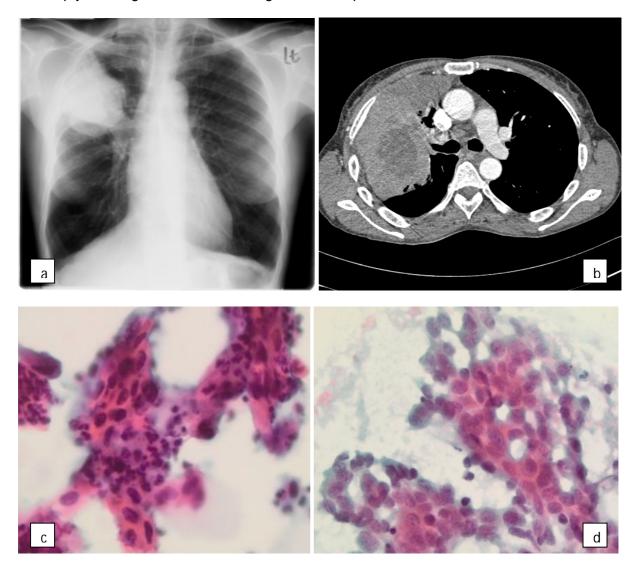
Mass in right upper lobe with associative collapse and lymphadenopathy on chest X-ray (a) and CT (b). Sputum - malignant. Sheets of keratinised cells with elongated, hyperchromatic nuclei (c). Bronchial brushing - Squamous cell carcinoma (d).
